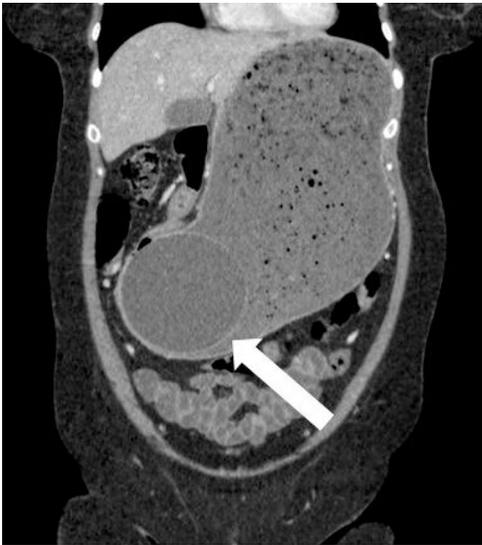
Oblique coronal CT image showing the same findings.
